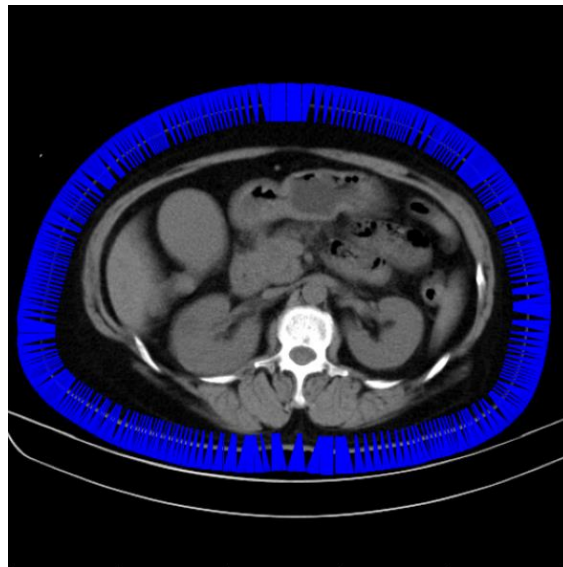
ROIs placement using the DT-ROI algorithm on patient CT image.
